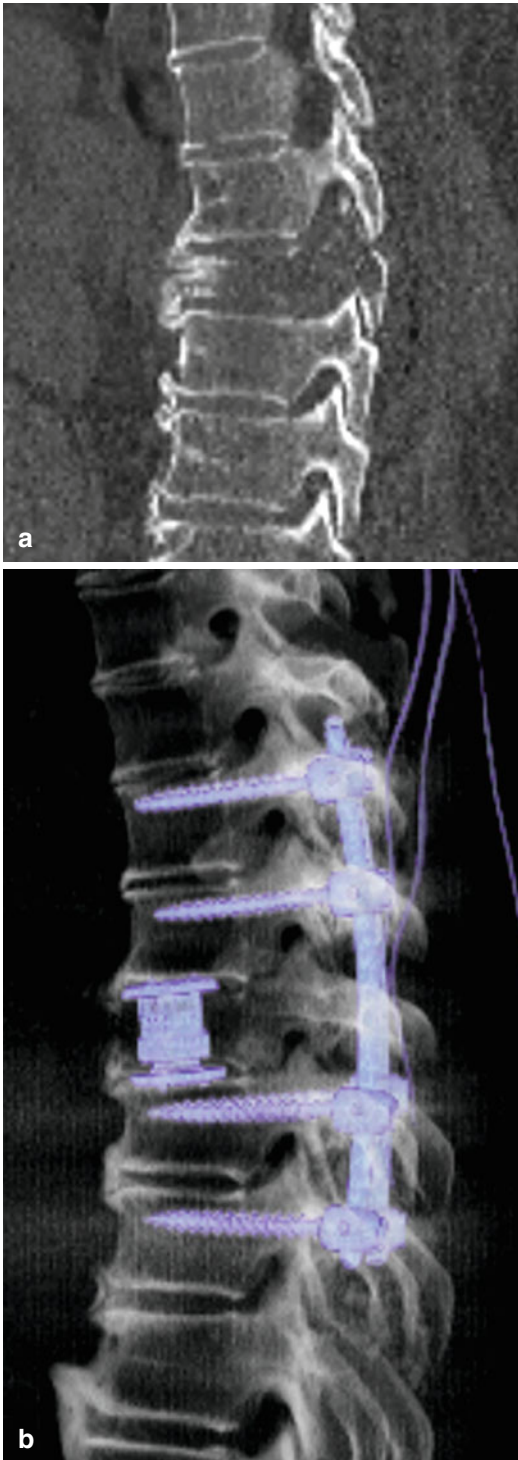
43 year old male with history of multiple myeloma A. Pre-operative sagittal CT reconstruction of the thoracic spine demonstrating a T8 vertebral fracture. B. CT scan status post vertebral corpectomy and pedicle screw and cage reconstruction
